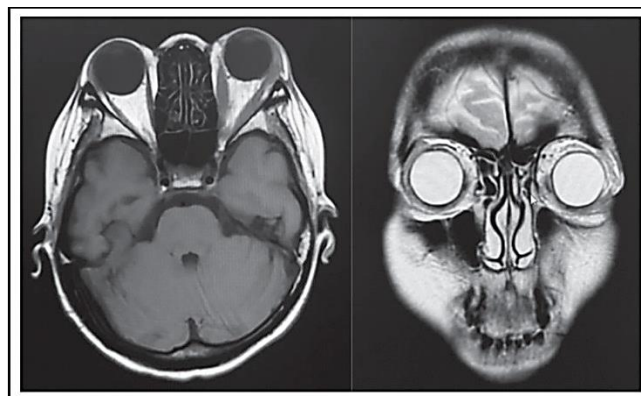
MRI and MRA with contrast.
